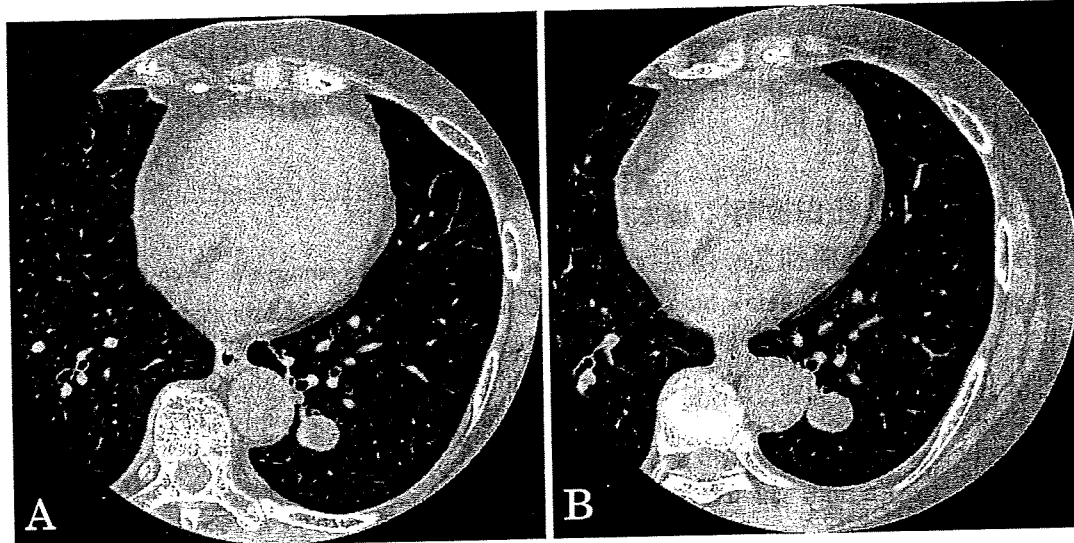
Chest CT findings. A. HRCT showing a well-defined nodule in the left S¹⁰ (taken at the time of the first hospital visit). B. HRCT showing a well-defined and slightly enlarged nodule in the left S¹⁰ (taken 3 months after the first hospital visit).
